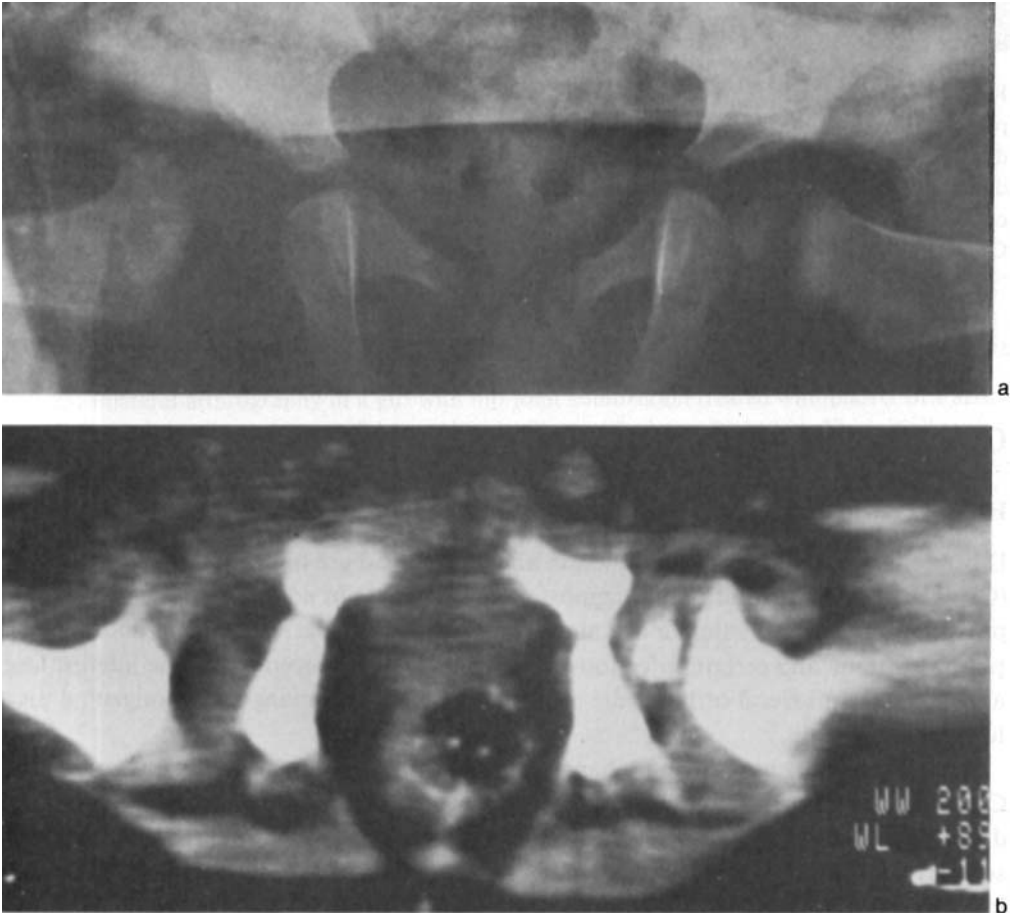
Computed tomography. CHD, discovered at the age of five months, after reduction and fixation in plaster.
